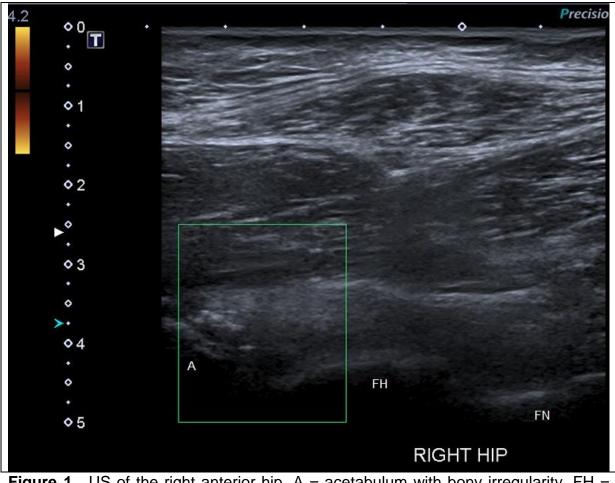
US of the right anterior hip. A = acetabulum with bony irregularity, FH = femoral head, FN = femoral neck. 1a) visualises the acetabular irregularity 1b) demonstrates no power Doppler flow in this area.
